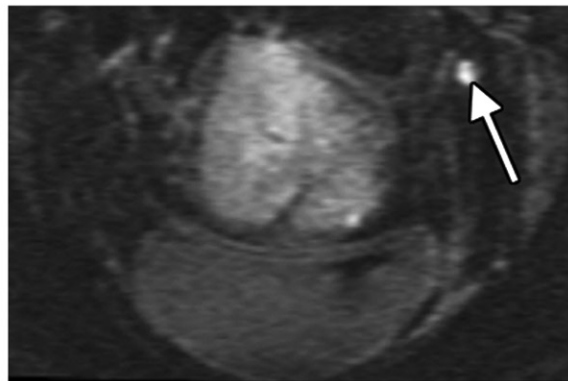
Cervical cancer in a 77-year-old woman. (a) Sagittal FSE T2-weighted MR image shows a large cervical mass (arrows). (b) Axial oblique T2-weighted MR image shows bilateral parametrial invasion (stage IIB) (arrows). (c) Axial oblique diffusion-weighted MR image shows a left pelvic lymph node (arrow), a finding suspicious for metastatic disease.
